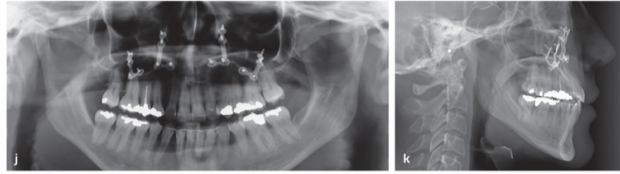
(cont) (j and k) Final panoramic and cephalometric radiographs.
